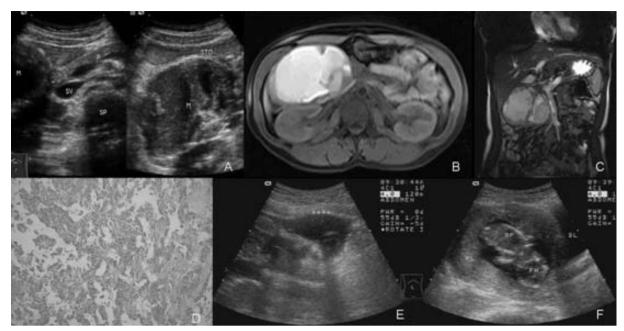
US revealed a well-circumscribed inhomogenous mass with intact amicula in the right of pancreatic head (A). MRI was performated to verify a giant solid-cystic mass with T1- and T2- weighted images in the right of pancreatic head (B-C). The pancreatic tumor showed marked cellular proliferation in the solid areas that alternated with a pseudopapillary and cystic pattern (D). US detected a local opaque dark area of fluid in the upper middle abdomen (E). Fetal position was good (F).
